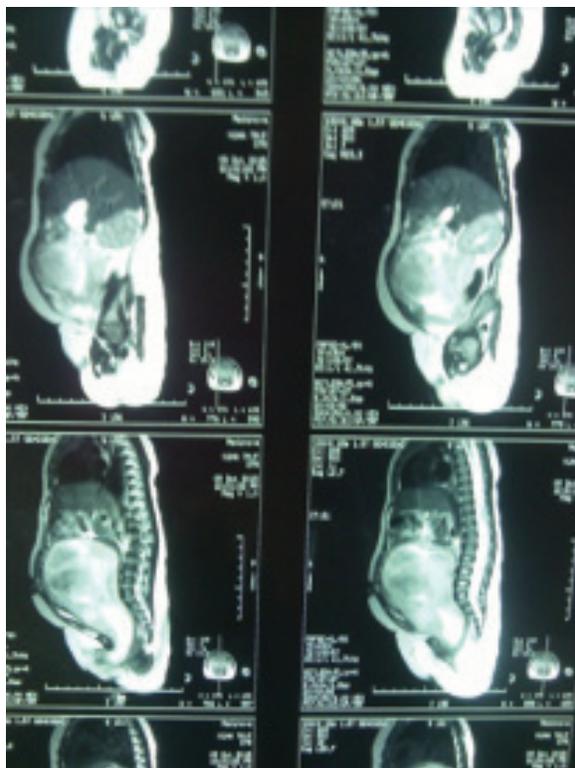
T2 weighted sequence of MRI showing contrast of the mixed intensity lesion
